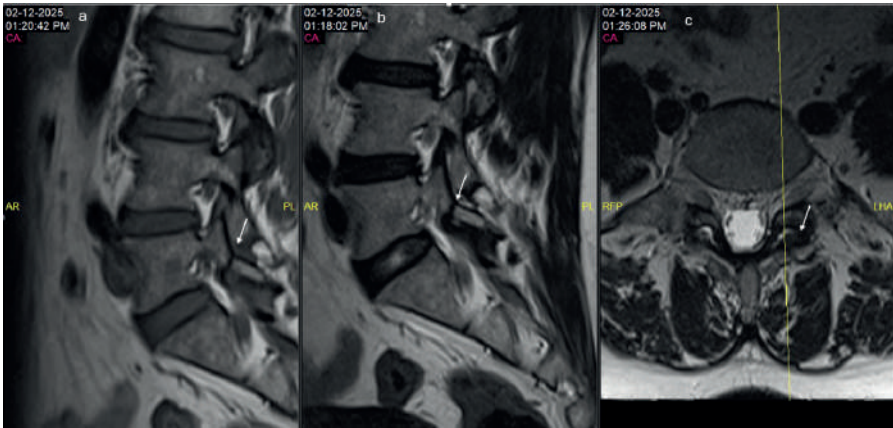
MRI demonstration of pars interarticularis defect on sagittal and axial images. Sagittal T1- and T2-weighted magnetic resonance images (a, b) and an axial section (c) of the lumbar spine demonstrating a defect in the pars interarticularis at the L5 level (arrows). The sagittal images show interruption of the pars continuity, while the axial image confirms the defect within the posterior elements. These findings are consistent with lumbar isthmic spondylolysis.
